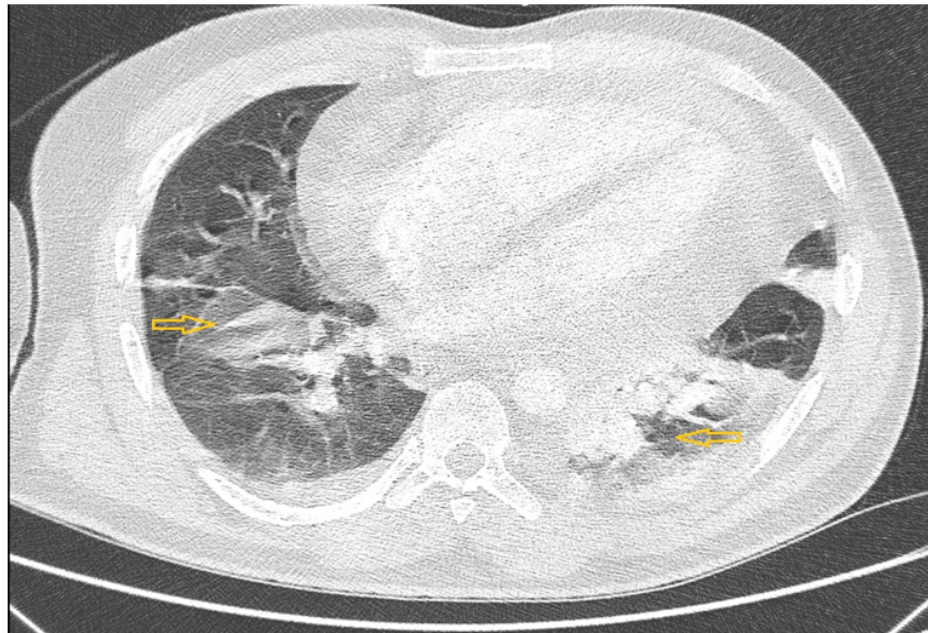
CT scan of thorax (lung windows) shows consolidation and ground glass changes at both bases.
